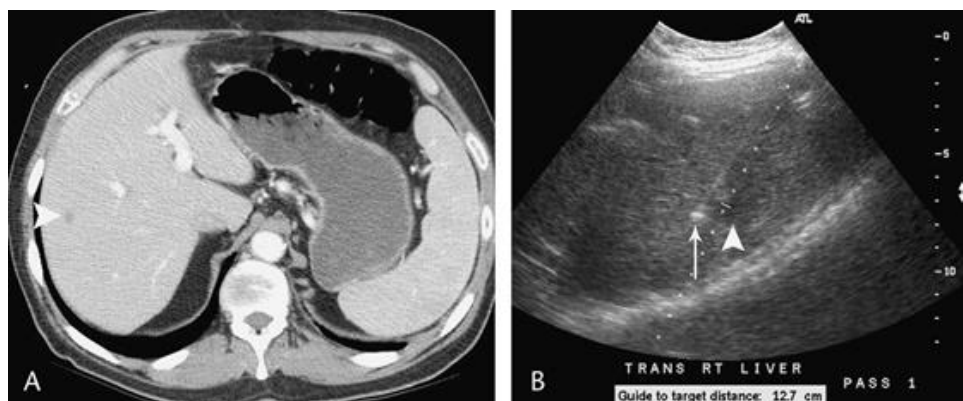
The needle deviates from the guidance. Metastatic pancreatic adenocarcinoma was diagnosed after three fine-needle aspirations of this lesion (arrowhead in CT [A]). Because the tissues above the 20-gauge needle drove it off course, the initial pass was lateral (B) to the lesion (arrowhead). Second and third passes (not visible) were inside the lesion and tumour, respectively. The arrow points to the needle tip.
